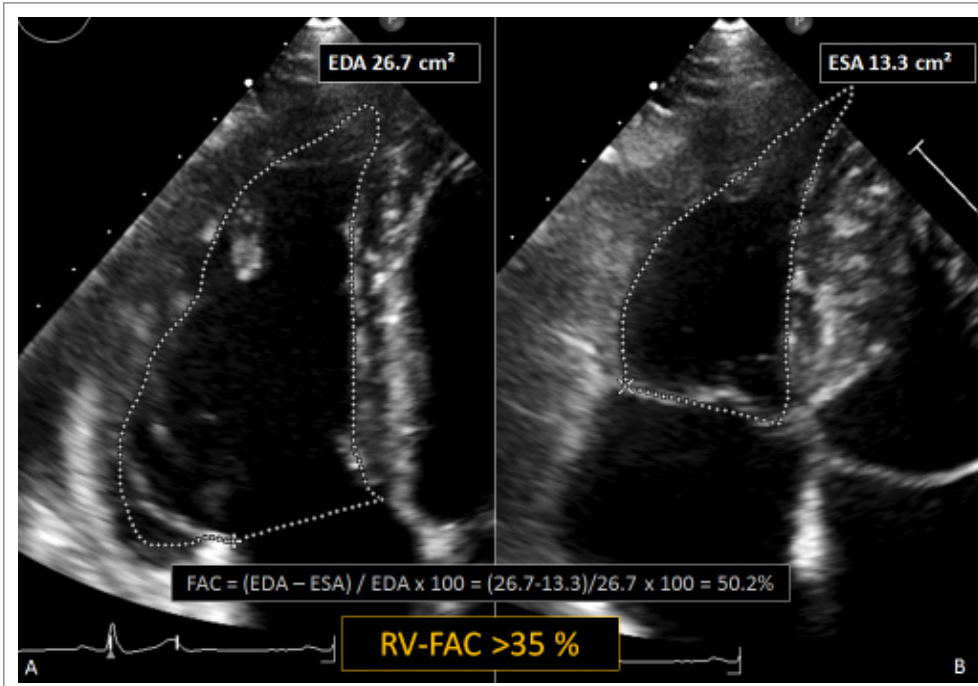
RV focused apical 4-chamber view for measuring RV areas (inflow) in order to calculate RV fractional area change (RV-FAC) from (A) end-diastolic area (EDA) and (B) end-systolic area (ESA). Presented RV-FAC (in yellow) displays the lower limit of normal for normal healthy adult individuals (20).
